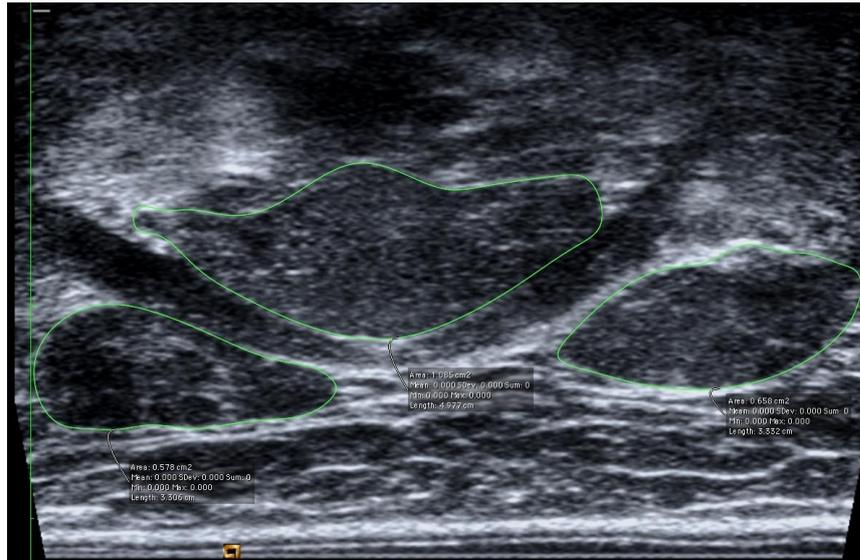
Ultrasonographic coronal image of submental muscles with anterior belly of digastric muscles and paired geniohyoid muscles outlined
